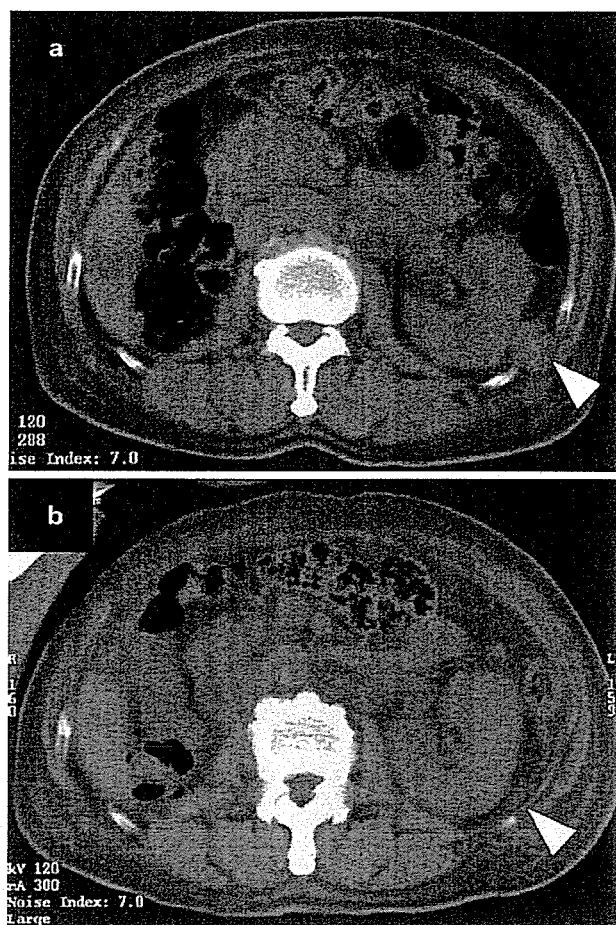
CT images of retroperitoneal metastasis (arrowheads) in a patient before second transplantation (a) and 2 months after second transplantation (b). Regression in the patient was concordant with the onset of acute GVHD of the skin and gut.
